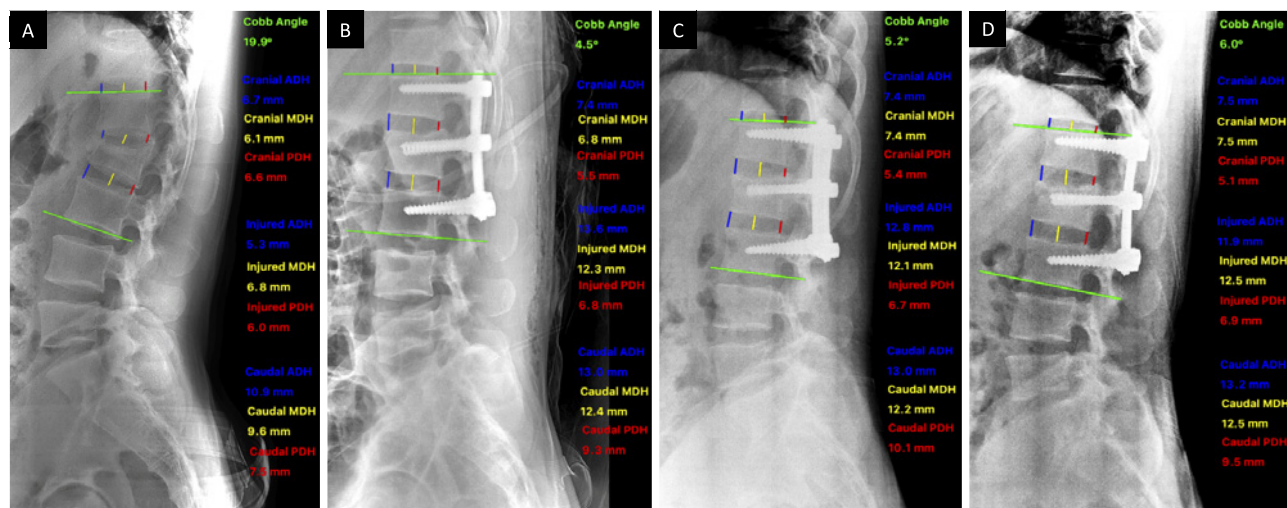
A 32-year-old male with fracture L2 (A3). (A) Preoperative lateral radiograph. (B) Immediate postoperative lateral radiograph after short segment fixation. (C) Lateral radiograph at recruitment (1-year post-fixation). (D) Lateral radiograph at the latest follow-up with retained metal. ADH, anterior disc height; MDH, middle disc height; PDH, posterior disc height
